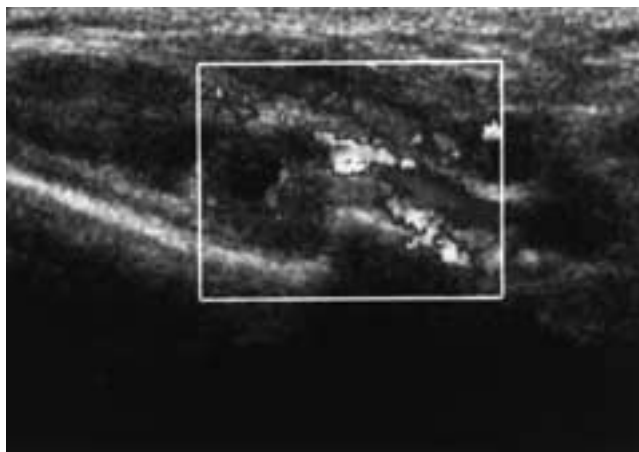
Cavernous hemangioma. Duplex Doppler ultrasonography shows a large, inhomogeneous lesion consisting of feeding vessels and larger sinuses that are seen as round or linear vascular areas. (Courtesy of Dr. F.J.A. Beek.)
